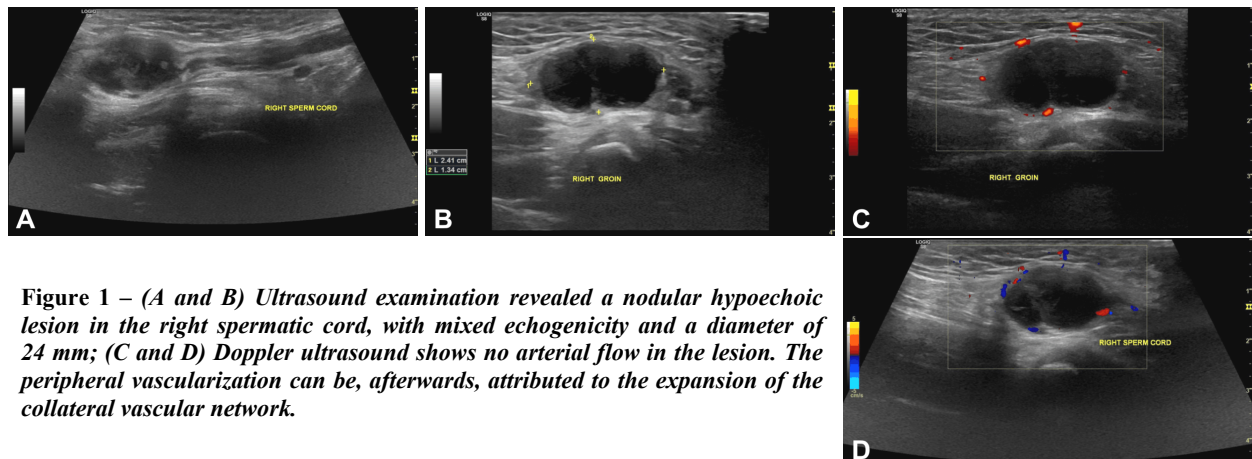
(A and B) Ultrasound examination revealed a nodular hypoechoic lesion in the right spermatic cord, with mixed echogenicity and a diameter of 24 mm; (C and D) Doppler ultrasound shows no arterial flow in the lesion. The peripheral vascularization can be, afterwards, attributed to the expansion of the collateral vascular network.
